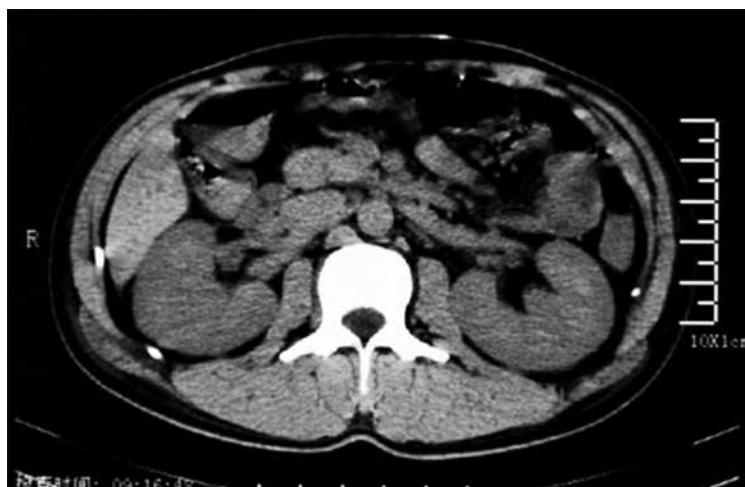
Abdominal CT scan of patient showing edema of kidney.
